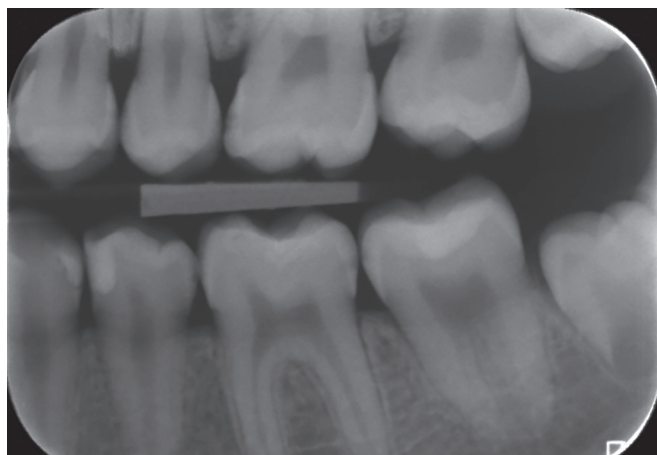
Bitewing radiographs on premolars and molars
